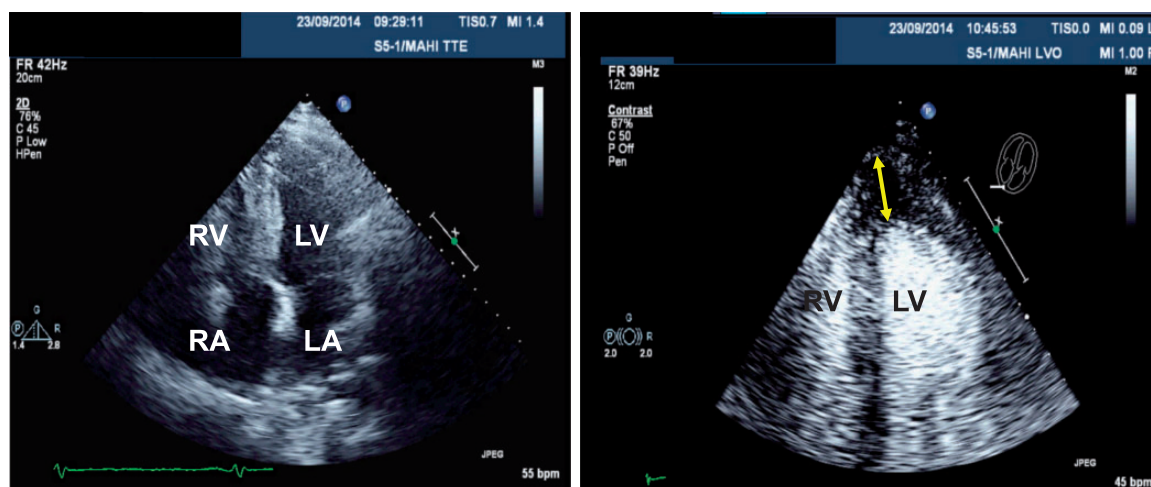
Apical hypertrophy not well displayed on the four chamber view without contrast (left), after injection of ultrasound contrast agent it was possible to measure the thickness of the apical myocardium.
